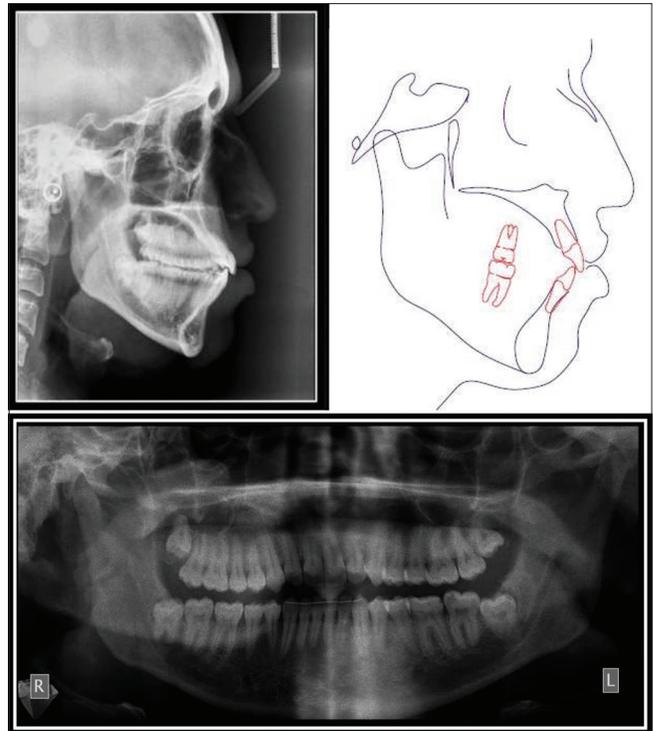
Post-treatment lateral ceph with tracing and panoramic radiograph
